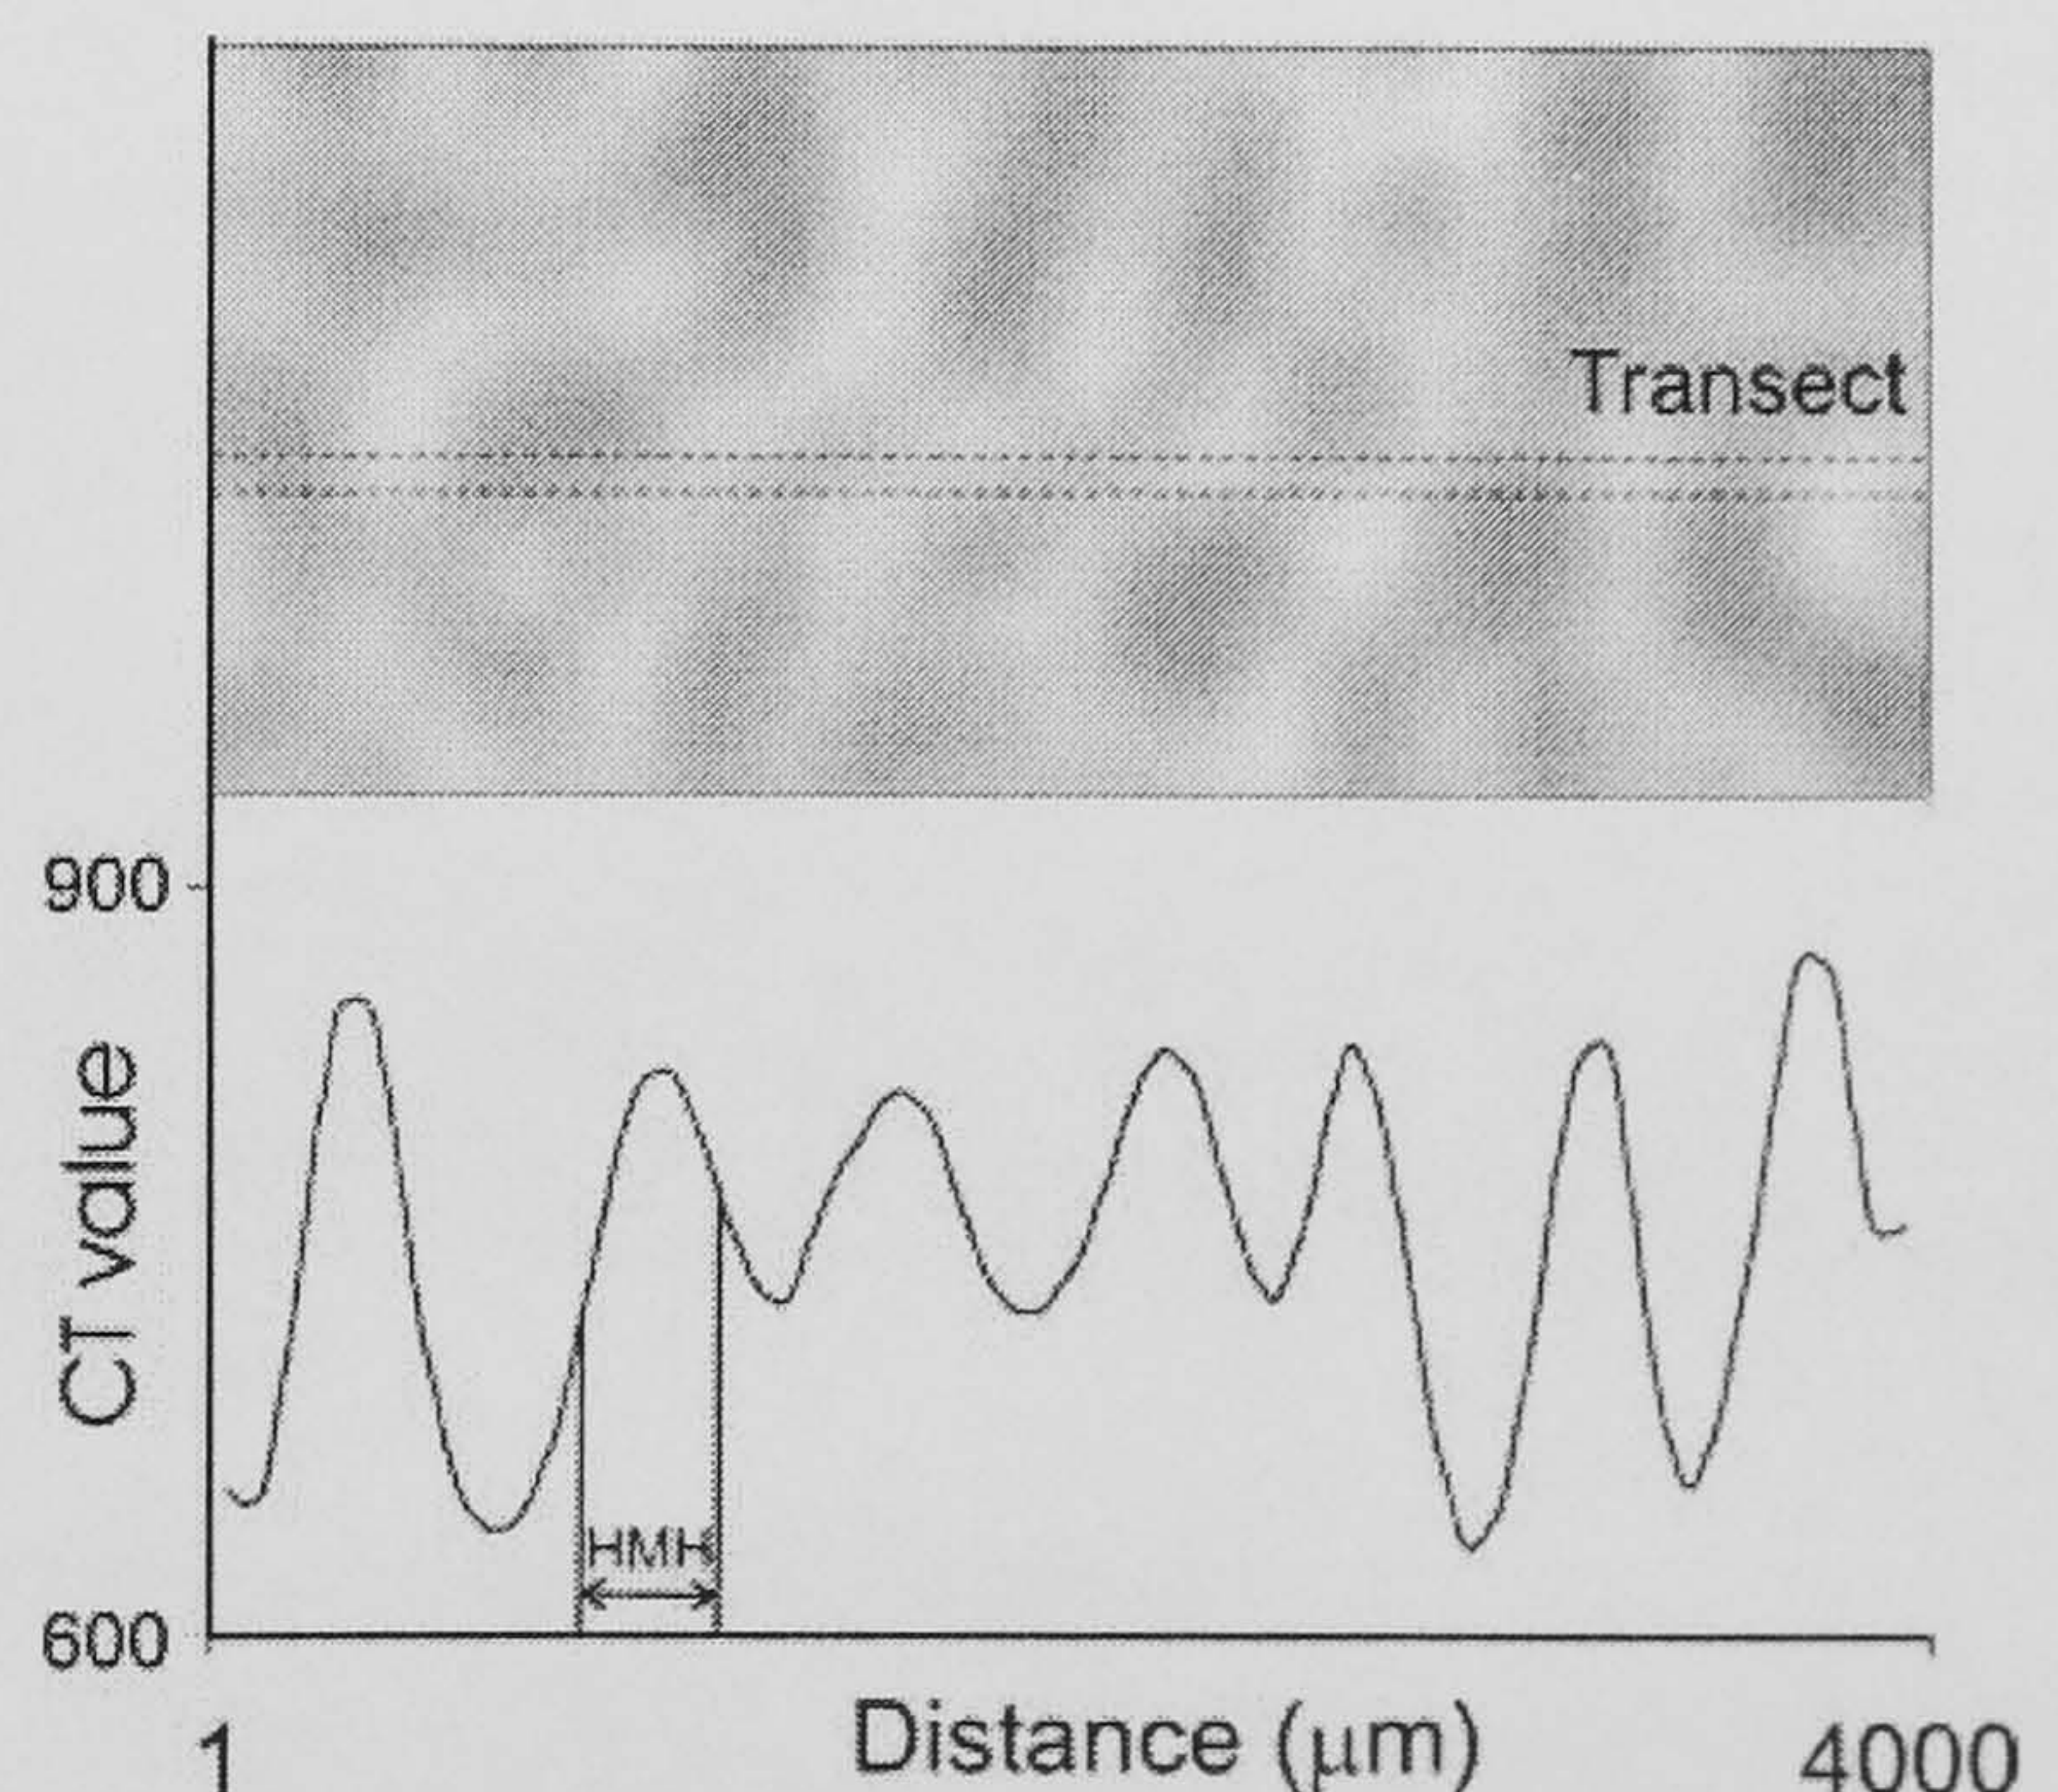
A section of a typical CT image of trabecular bone is shown (top) and the CT value profile for the transect indicated above is given (bottom). For one trabecula, the HMH is identified and the width given.
